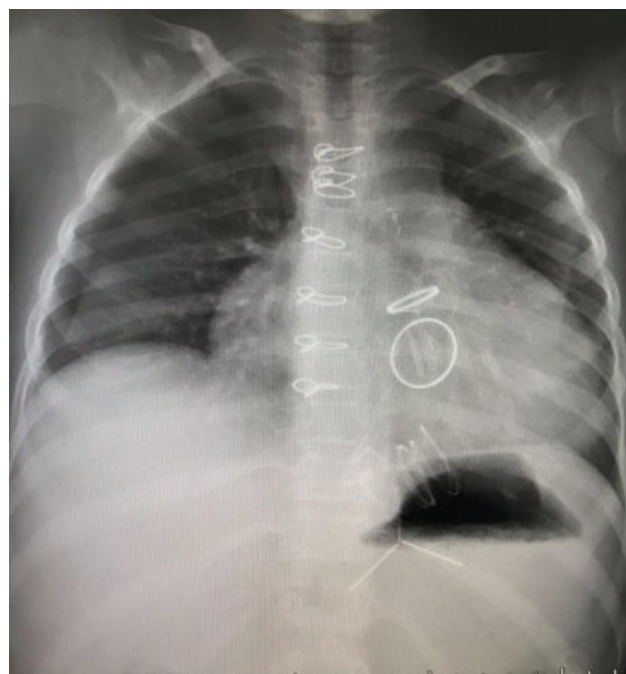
Chest X-ray demonstrating the mechanical replacement of the mitral valve and the aorta valve after cardiac surgery.
